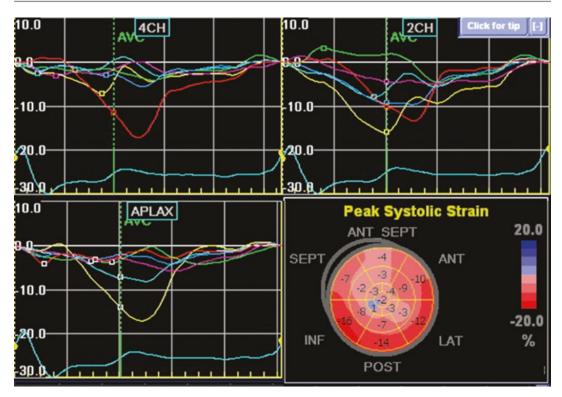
A heterogeneous pattern in the upper left panel (apical four-chamber view) from a patient with heart failure. Other views are mostly heterogeneous. Only walls
